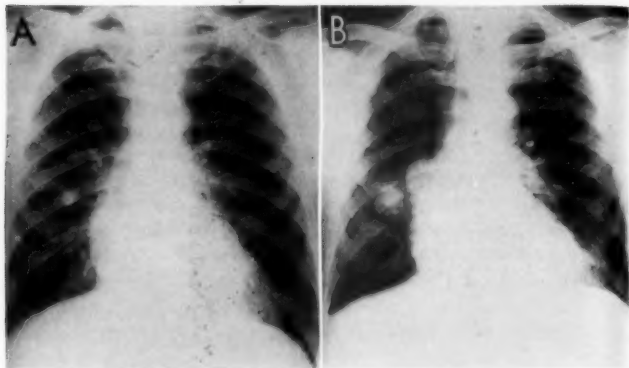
A routine chest roentgenogram (A) of a man, aged 59, revealed a 2-cm. nodule in the right midlung field. Three years later (B), the nodule showed concentric enlargement associated with marked hilar lymphadenopathy. Despite a recent coronary thrombosis, operation was advised. An extensive squamous carcinoma was encountered, but the patient has remained well for nearly 4 years following pneumonectomy.
